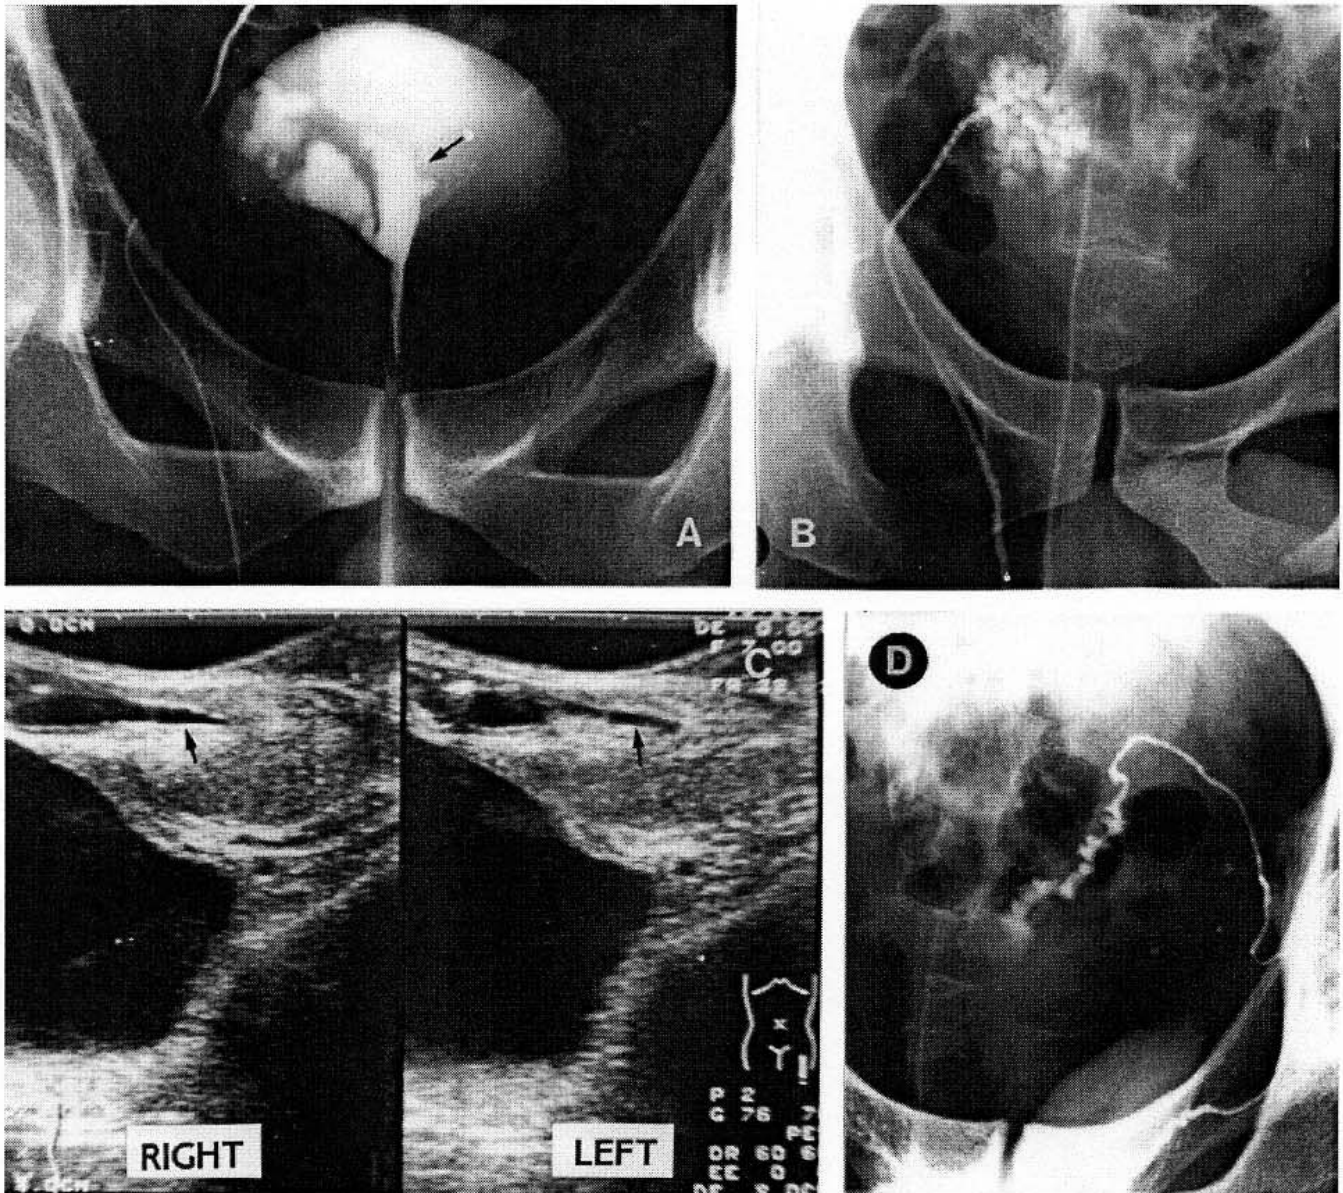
Imaging of the preserved seminal tract in some CUAVD patients. (A) Right vasogram of an azoospermic patient with left CAVD and normal *CFTR* genotype. The right vas deferens is patent, ending on a dilated ampoule with small diverticula (arrow). The seminal vesicle is dysplastic and the ejaculatory duct appears enlarged. Passage of contrast to urethra was difficult but possible. (B) Vasogram of a patient with azoospermia and left CUAVD, normal *CFTR* genotype. The lumen of the right vas deferens is dilated and irregular, connected directly to a dysplastic seminal vesicle, without communication with the distal seminal tract. (C) Transrectal ultrasonography of an azoospermic patient with right CUAVD and a *CFTR* genotype L383S/ST. Both ejaculatory ducts appear dilated, and the seminal vesicles are of normal size (arrow). (D) Left vasogram of this patient ends on a tortuous ampoule with no visible communication with seminal tract.
